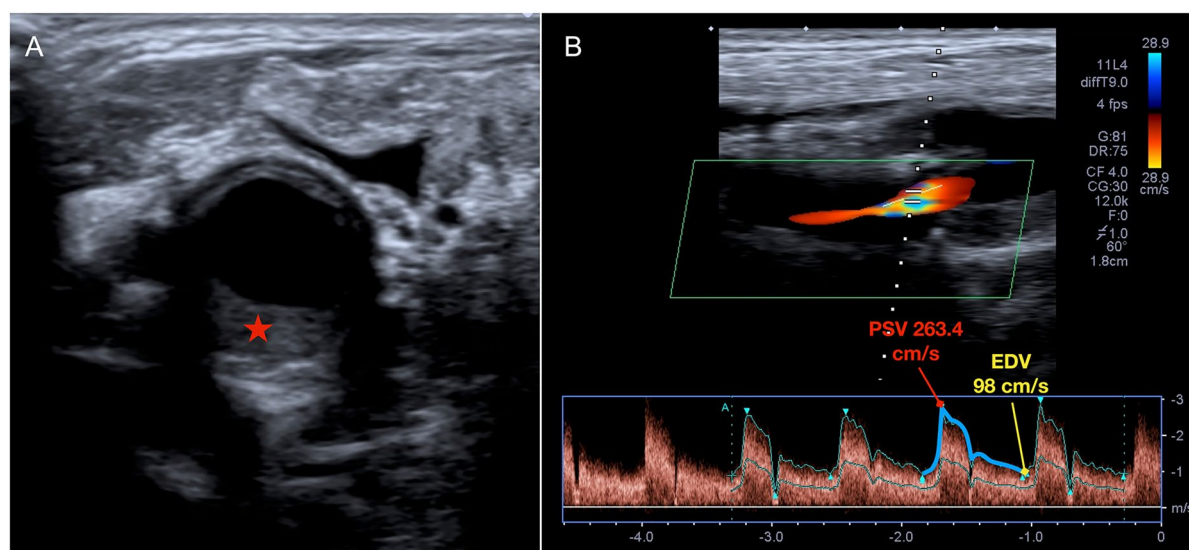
Ultrasound imaging of the carotid bifurcation. A Cross-sectional ultrasound view of the CCA reveals an echolucent plaque (*red asterisk*) causing luminal narrowing. B Longitudinal view showing the plaque extending into the origin of the ICA. Doppler velocity analysis indicates
